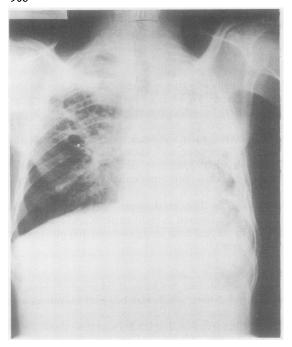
Chest radiograph of patient 1 at presentation showing extensive bilateral consolidation with cavitation.
